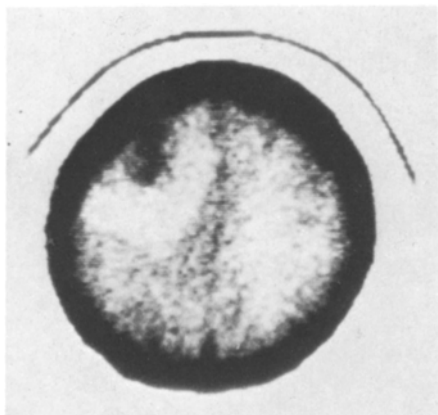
CT scan section showing the frontal tumoral mass and the peritumoral swelling reaction
